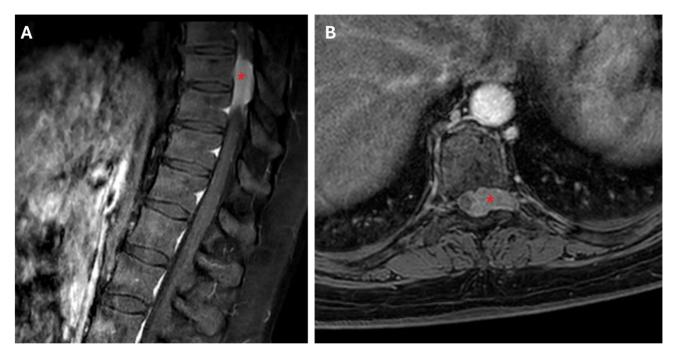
Preoperative thoracic spine MRI. Sagittal (A), and axial T1-weighted image (B) with and without contrast enhancement reveal an intradural-extramedullary lesion at the Th9–Th10 vertebral level (red asterisks). The lesion displays a "dumbbell" shape, extending through the intervertebral foramen, and measures approximately 3.5 cm at its greatest dimension (Eden type 2). This picture is from S. Elia Hospital, Caltanissetta, Italy, and informed consent was obtained from the patient for this study.
